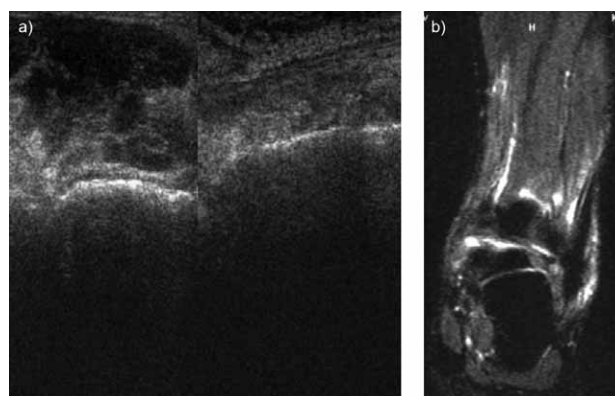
a) (Ultrasound). Left: Rupture (Lesion G3) of the left Calcaneofibular ligament Right: Normal ligament on the contra lateral side; b) (Magnetic resonance). Rupture (Lesion G3) of the left Calcaneofibular ligament.
